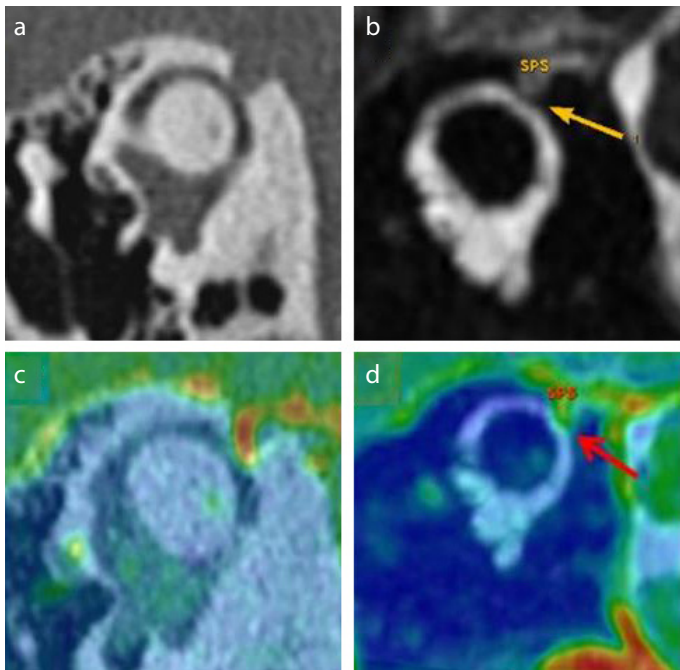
a-d. Case report 3 – Class C. a) right ear high-resolution computed tomography (HRCT) Pöschl plane. “Cookie bite” aspect, superior semicircular canal dehiscence (SSCD) by superior petrosal sinus (SPS) (length measured at 1.7 mm). b) T2 HR drive RMI sequence showing a labyrinthine compression. c) Fusion between HRCT and 3D T1 weighted enhanced sequence. d) Fusion between 3D T1 weighted enhanced and T2 HR FIESTA sequences. SPS compression on the SSC.
